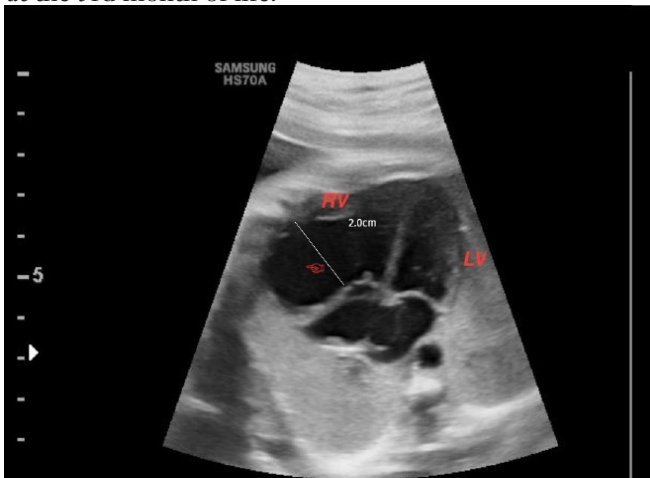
Fetal ultrasonographic four-chamber view showing the aneurysm arising from the right ventricle with a broad base. RV; right ventricle LV; left ventricle
